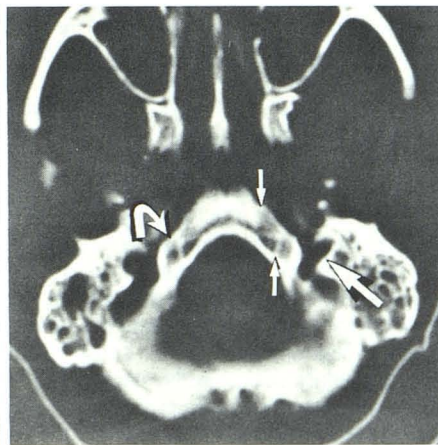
CT of dried skull demonstrates anterior and posterior borders of pseudofoamena (small arrows), showing relationship to hypoglossal canal (curved arrow) and jugular foramen (large arrow).
